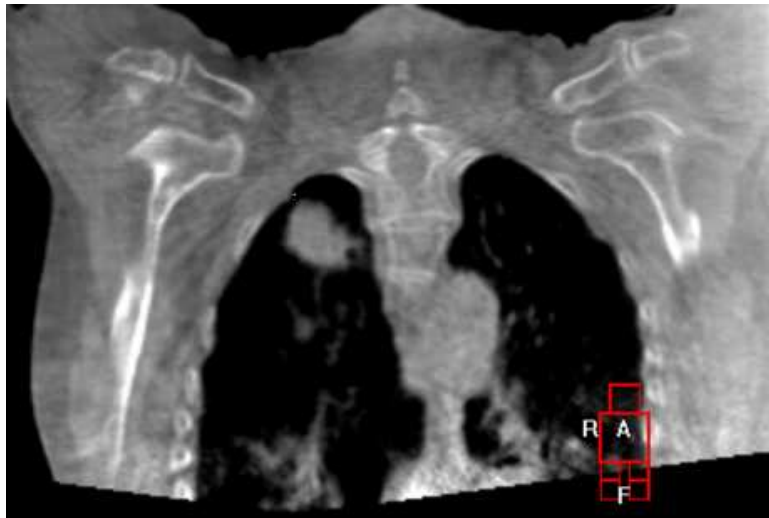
A coronal view of the CBCT of a lung cancer patient.
